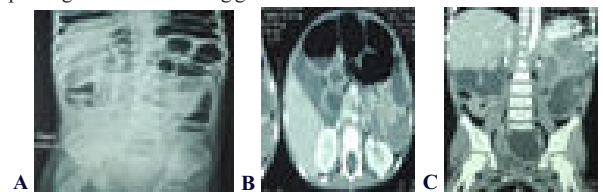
A-X-RAY Abdomen shows multiple air fluid levels suggestive of small bowel obstruction
